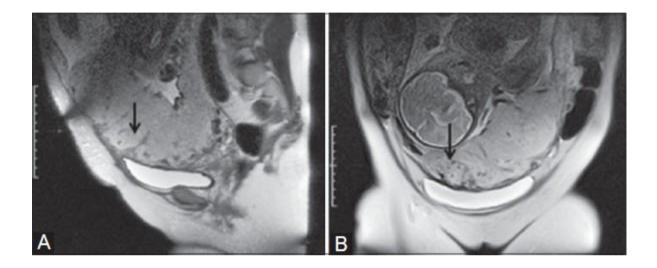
A)&B).Sagittal & Coronal MR images showing a complete previa with increta heterogenous placenta(arrows)due to thick intraplacental bands and abnormal vascularity.
